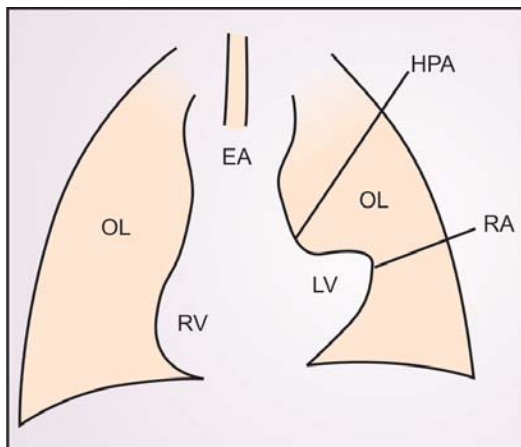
Classical X-ray appearance of Fallot's tetralogy.
